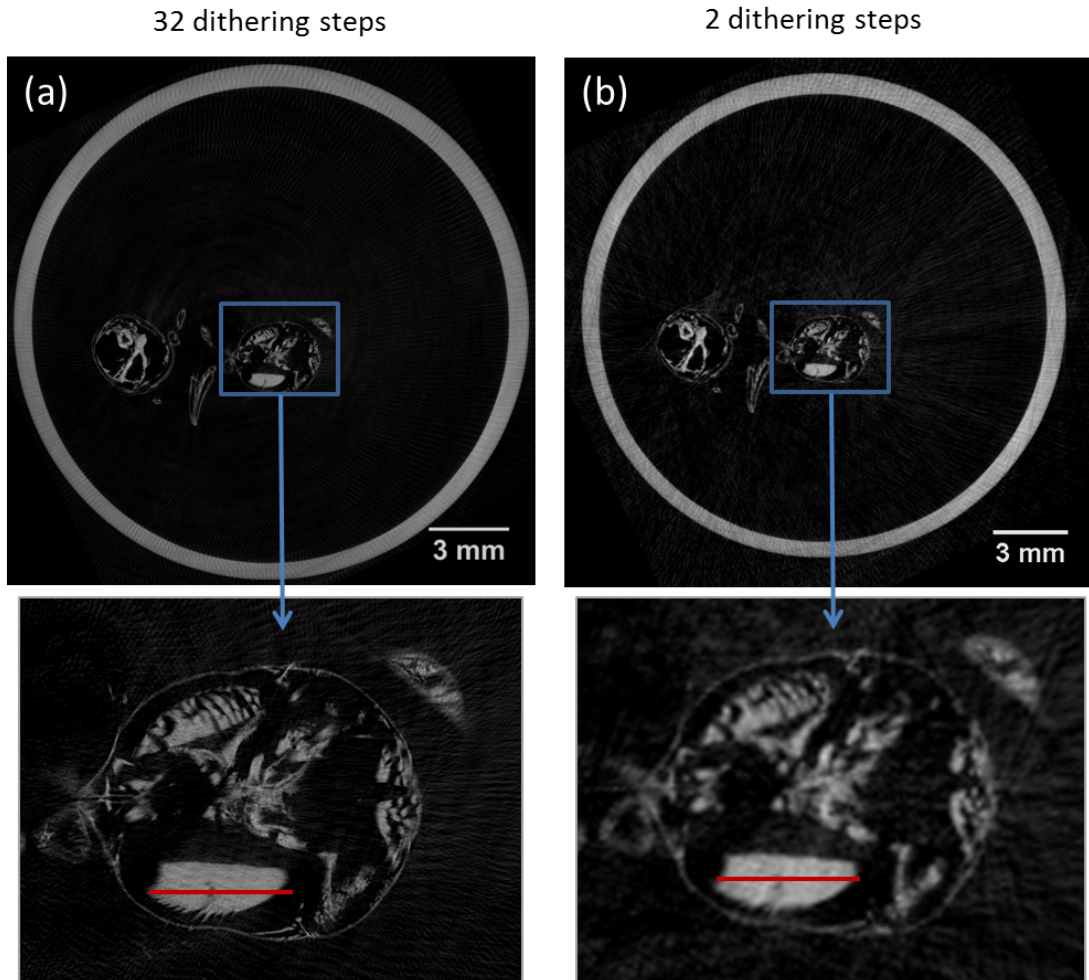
Transverse slices showing the RID of a domestic wasp, reconstructed from EI-CT datasets acquired with 32 (a) and 2 (b) dithering steps. Larger views of the indicated areas (the insect's head) are provided.
